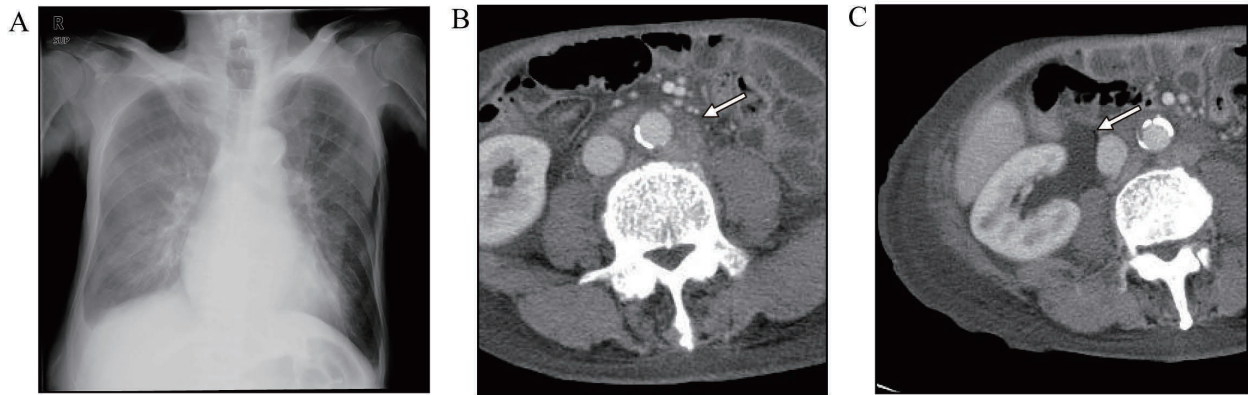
(A) Chest X-ray on admission. (B) Abdominal computed tomography with contrast media showed swelling of the abdominal paraaortic nodes. (C) A mass due to swelling of the external iliac lymph nodes and hydronephrosis derived from compression of both urinary tracts.
